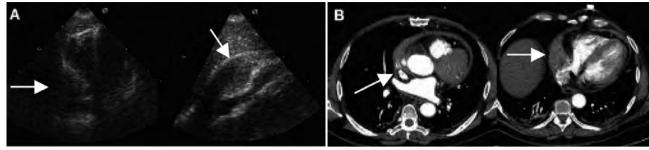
A) Transthoracic echocardiogram. Left: apical window 4-chamber view showing compression of the right cavities. Right: Subcostal window showing half-moon image of heterogeneous echogenicity in the right atrioventricular groove hematoma compressing the right cavities. B) Contrast CT scan of the chest. Left: extravasation of contrast medium at the right posterior level of the ascending aorta. Right: atrioventricular groove hematoma compressing the right cavities.
